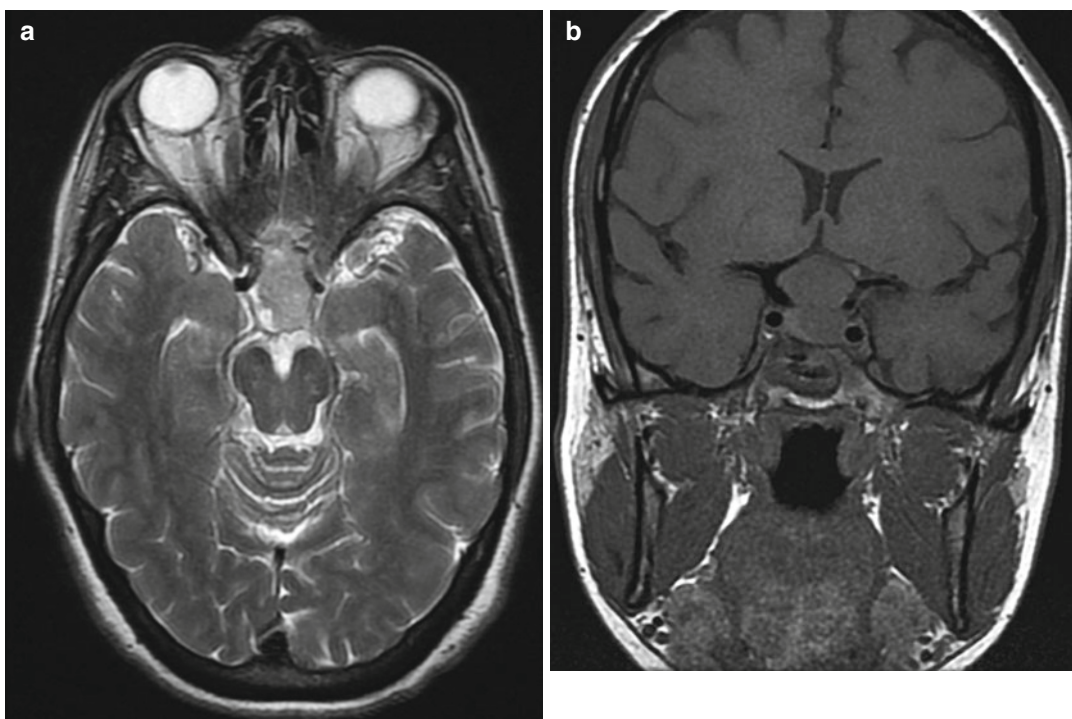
(a–f) MRI sequence: (a) axial T1, (b) coronal T1, (c) coronal enhanced T1 and (d) sagittal T1) of a 40-year-old woman presenting with classical apoplexy, who suffered sudden and worsening severe headache and new bitemporal visual field loss. Scans (a–d) show a mixed density lesion in and above the pituitary fossa compressing the chiasm. Note the multilobulated lesion with narrow waist and the prefixed chiasm pushing the adenoma back over the sella. This is a difficult surgical target. Operated by
